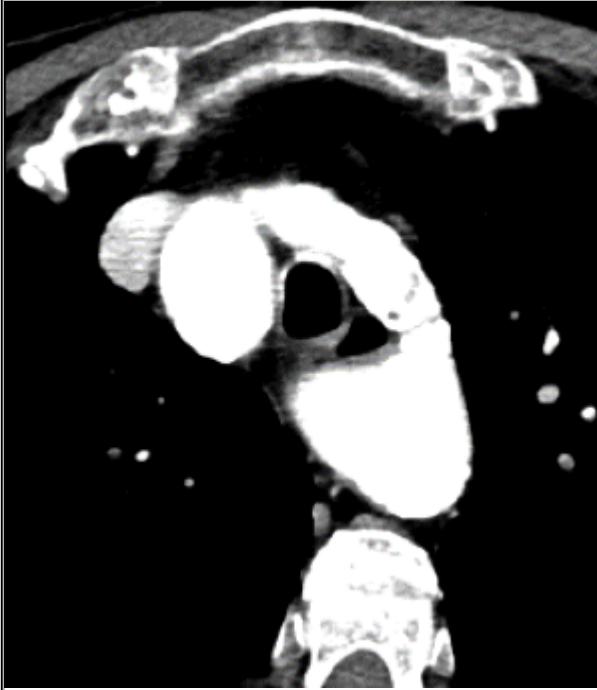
CT angiography, axial images through the upper mediastinum.
